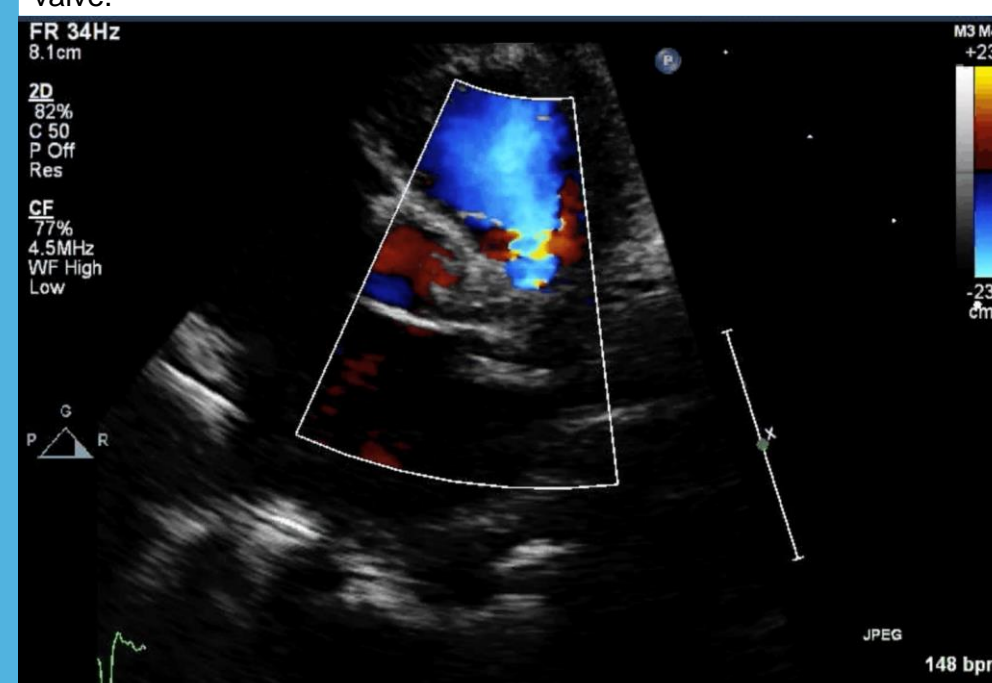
Parasternal short axis view of the aortic valve showing a thrombus at the origin of the left main coronary artery and no flow in the left coronary system.
